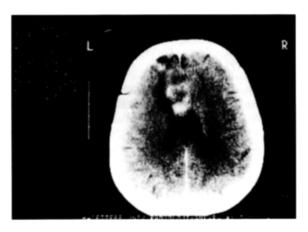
Case 3. CT scan showing a calcified, contrast enhancing lesion in deep left frontal lobe.
